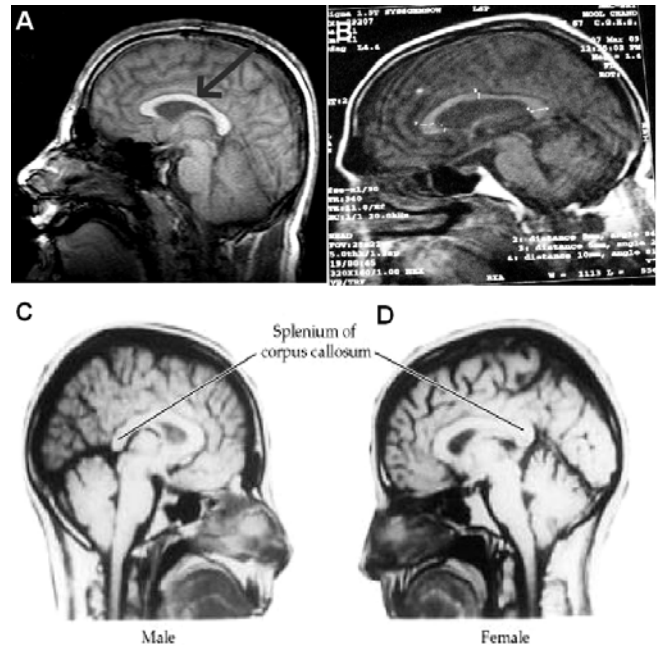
Showing position of corpus callosum in mid-sagittal view of MRI (arrow) (A), and thickness of its different parts (B) and position of splenium in male (C) and female (D).
